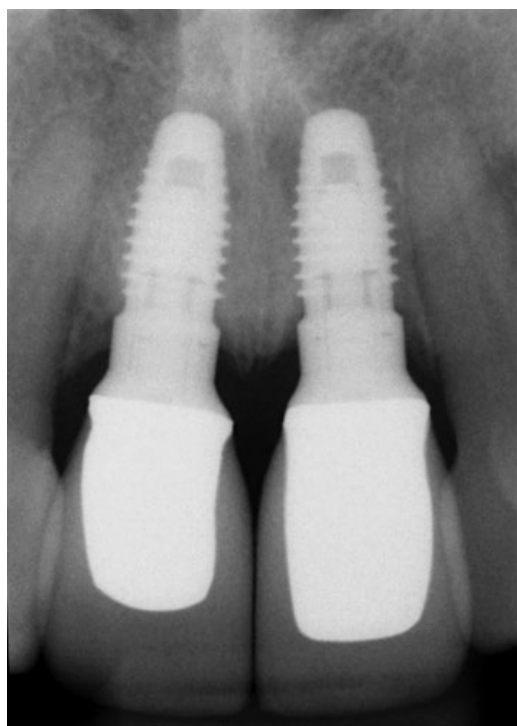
(B) Radiograph of the implants number 8 and number 9 after 8 years in function. Bone levels are normal with evidence of remodeling around this implant design to the first major thread (Nobel Replace Select, Nobel Biocare, Yorba Linda, CA).
